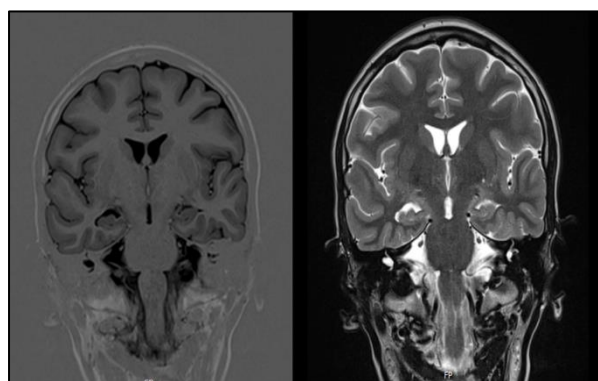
Cranioencephalic MRI showing aplasia of lateral SCC with vestibule dilation.
